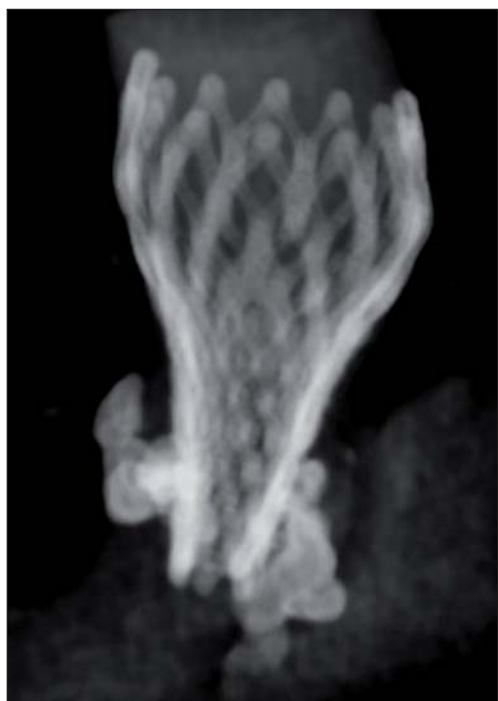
A visualization (CT) of elliptic distortion of CoreValve implanted in BAV.
